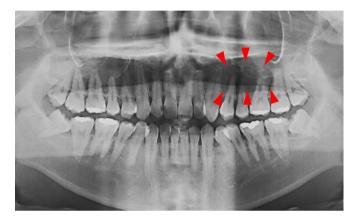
A panoramic radiograph taken at the initial examination. A panoramic radiograph demonstrated a round radiolucent area of an intraosseous lesion, with a well-defined border (arrowheads) in the left maxilla extending from the first premolar region to the first molar region.
